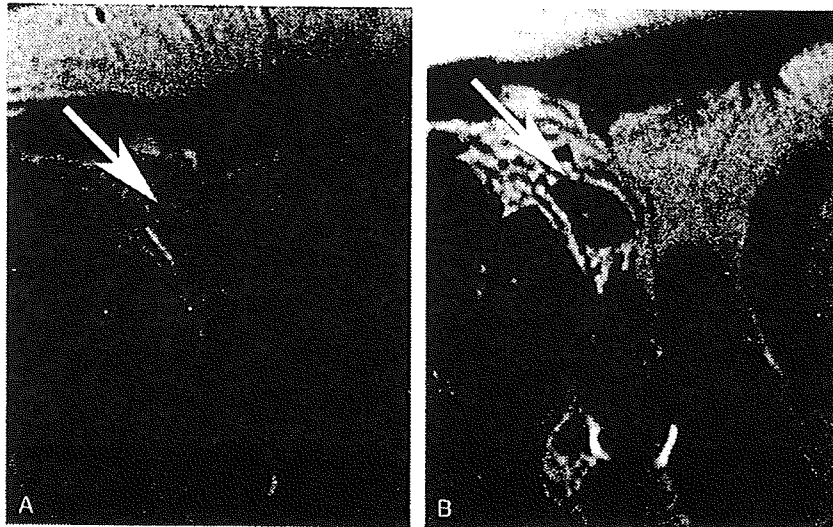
磁性体微粒子 MRI 造影剤を用いたリンパ節転移の診断
